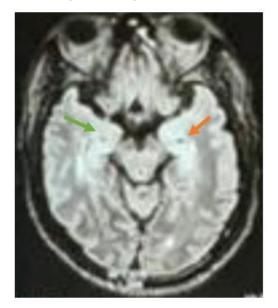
1.5 Tesla Brain MRI scans (case 4) A) Coronal and Axial B) T2 Flair sequences showing bilateral hypersignal in the medial temporal lobe structures.
